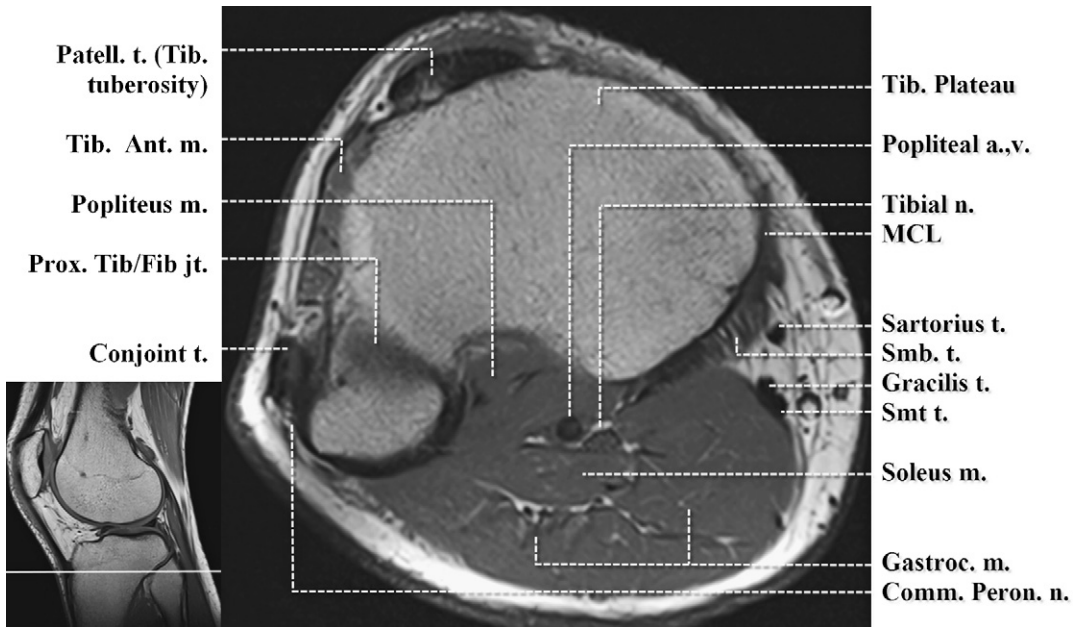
Axial T1-weighted image. Proximal tibia/fibula. a., artery; Comm. Peron. n., common peroneal nerve; Gastroc., gastrocnemius; Iliotib., iliotibial; m., muscle; MCL, medial collateral ligament; n., nerve; Patell., patellar; Prox. Tib/Fib jt., proximal tibiofibular joint; Smb, semimembranosus; Smt t, semitendinosus; t, tendon; Tib. Ant, tibialis anterior; Tib, tibia; v, vein.
